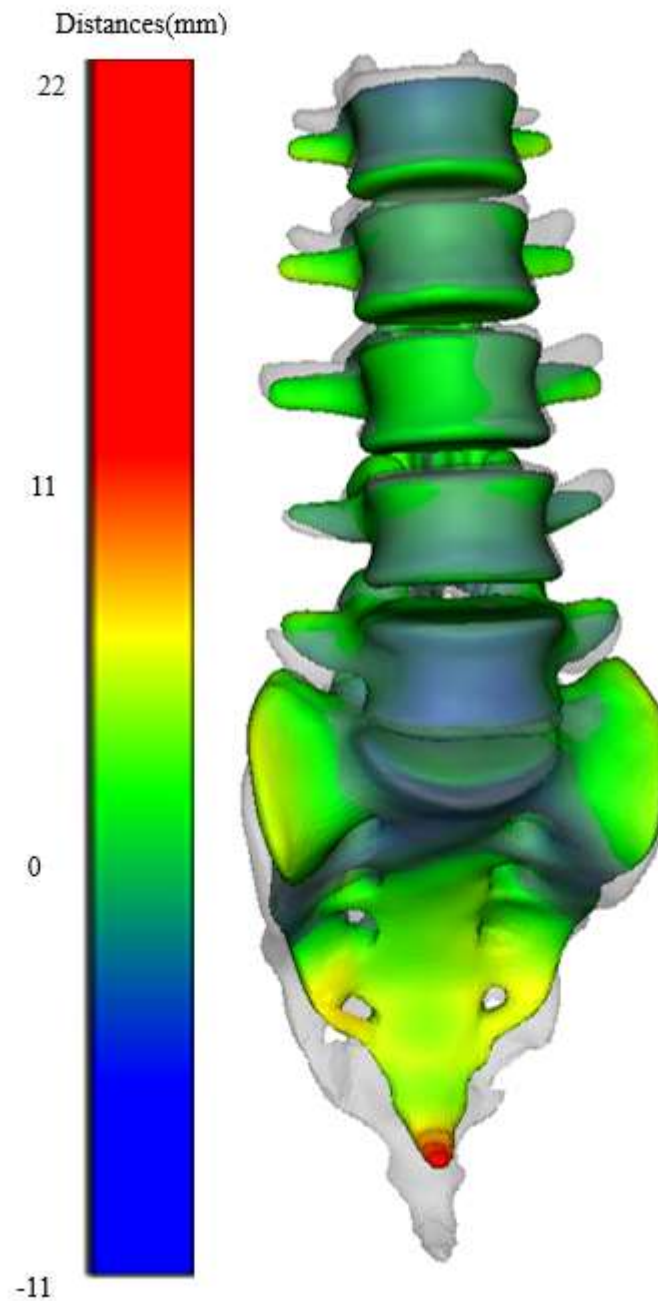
Comparison of lumbar spine (without pelvis) prediction with the CT reconstructed mesh (anterior view)
